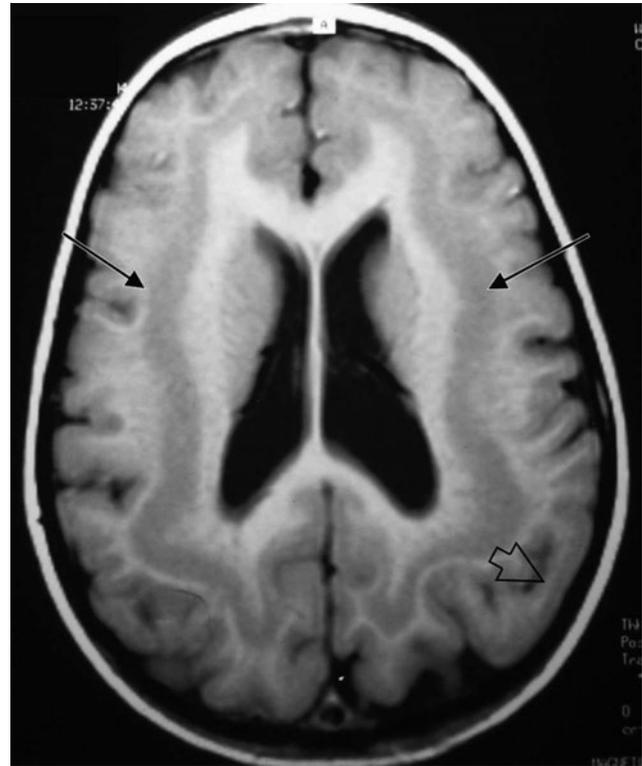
Axial T1-weighted magnetic resonance image of a child with subcortical band heterotopia (double cortex). The bands of gray matter are situated between the lateral ventricles and cerebral cortex (arrows). Note the associated pachygyria (open arrow).
